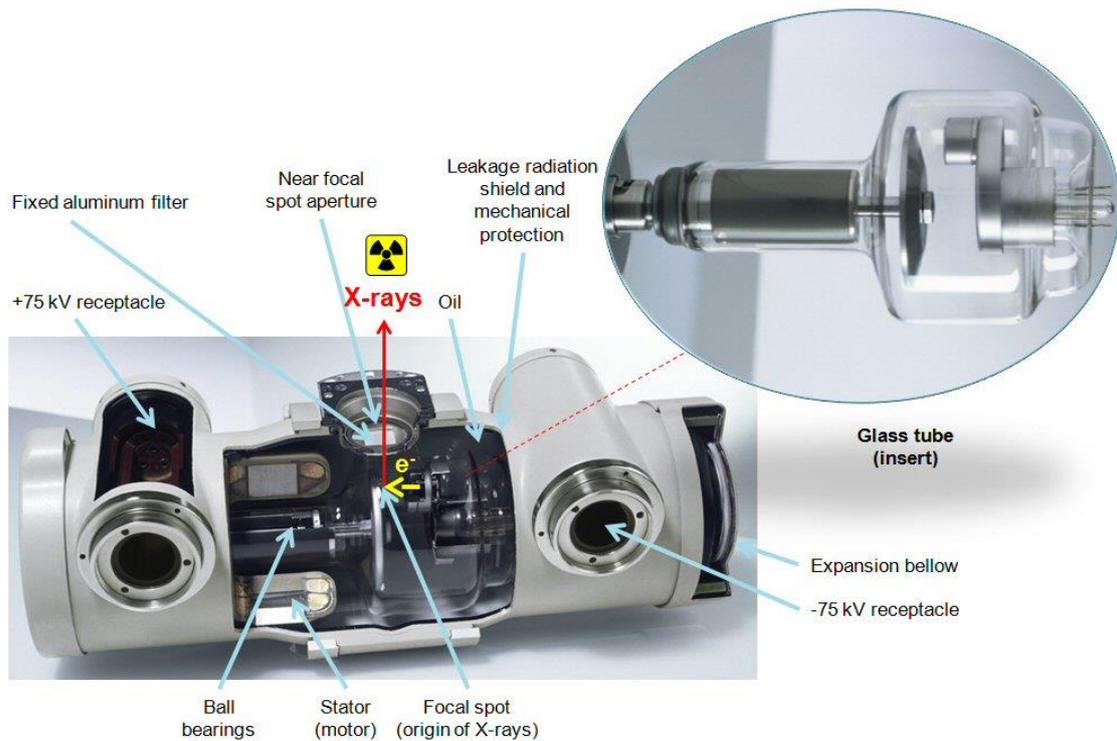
Function and major components of a conventional radiographic X-ray tube assembly from Philips, which has been in production in similar form since the 1950's.
